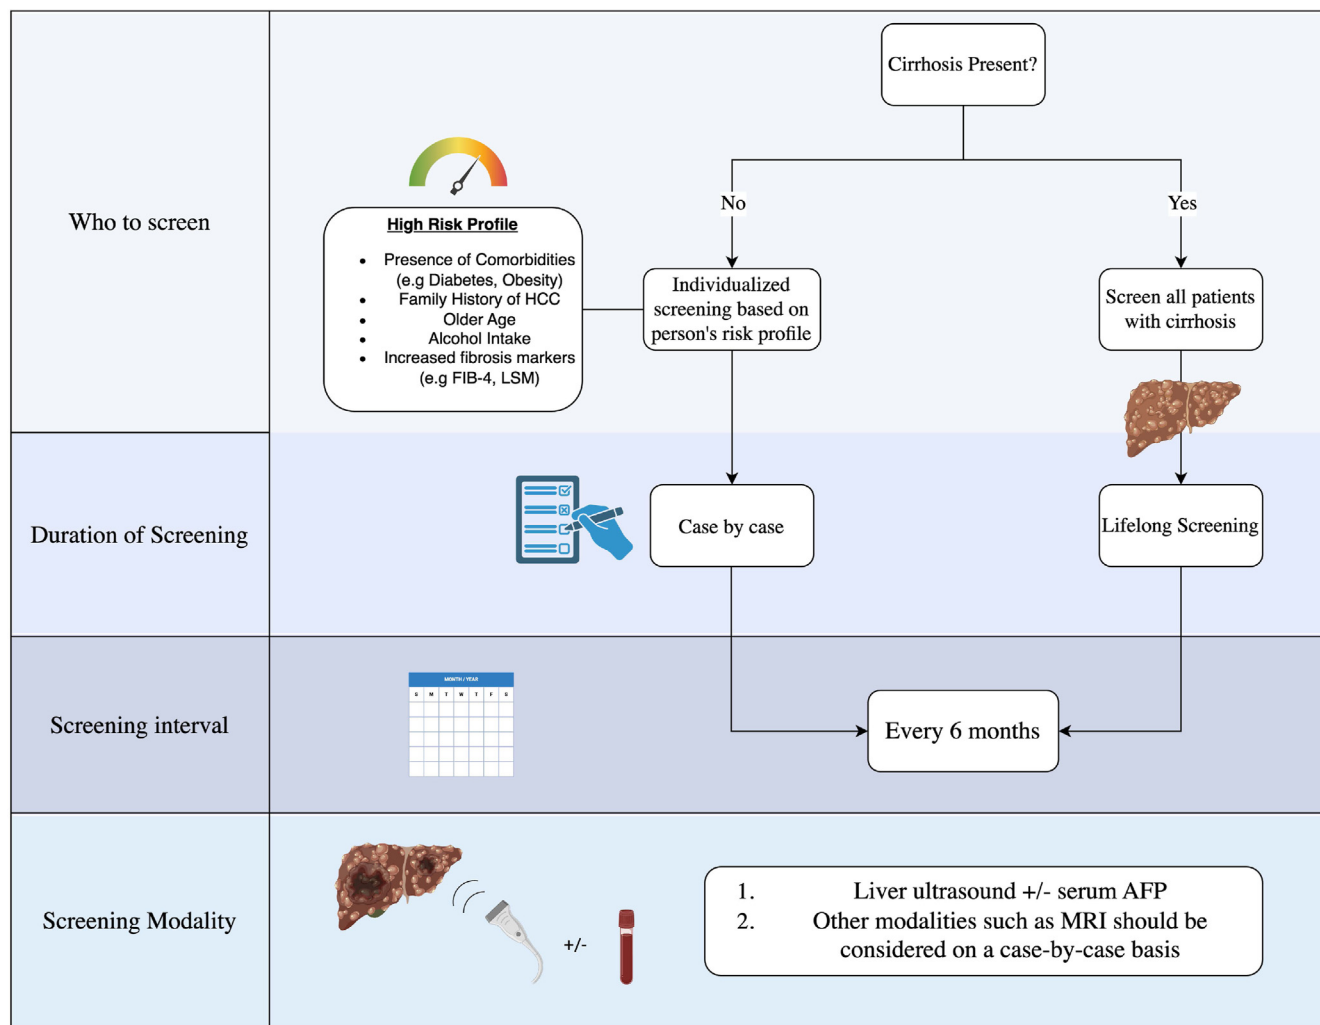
Hepatocellular carcinoma screening recommendations. MRI, magnetic resonance imaging.
